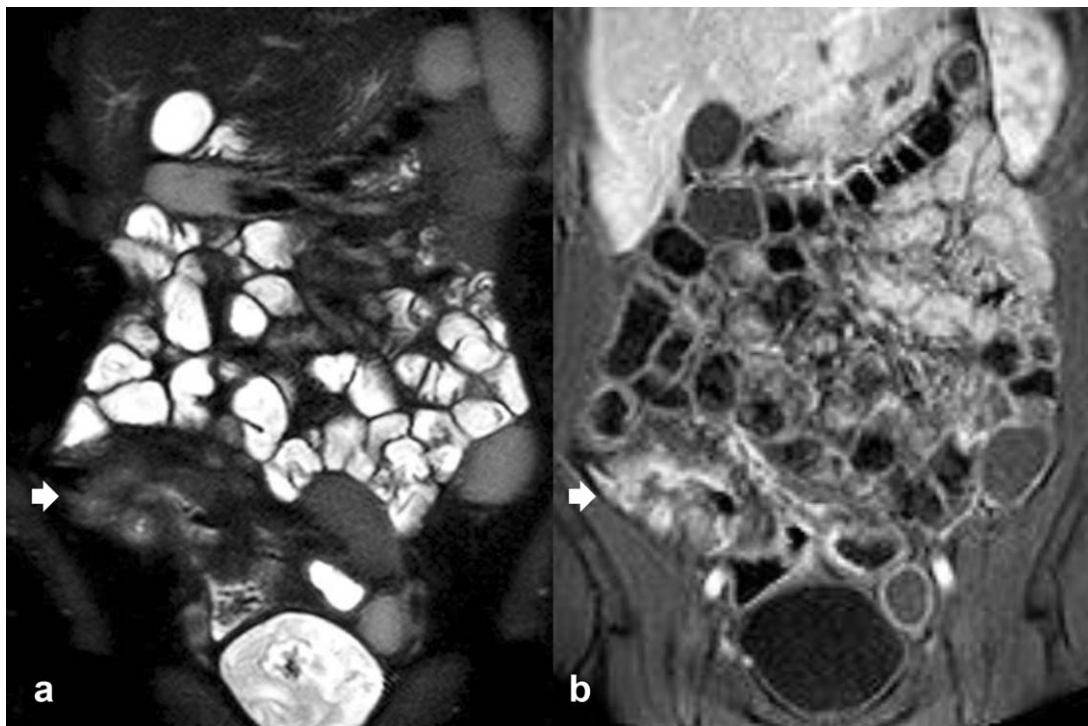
A 55-year-old woman with active CD. (a) T_2 -weighted SPAIR MR images with fat suppression. (b) THRIVE with fat suppression MR images acquired in the coronal plane after injection of gadobenate dimeglumine during the arterial phase. (a) Focal thickening of the cecal and ileal wall (arrow) with stricture of the bowel lumen. The bowel wall appeared thickened but presented equivocal mural intensity (arrow) according to both readers, who were not able to define the presence or absence of disease activity. After contrast injection the involved ileal tract shows transmurial enhancement corresponding to active inflammation which was confirmed at endoscopy (CDEIS = 14).
